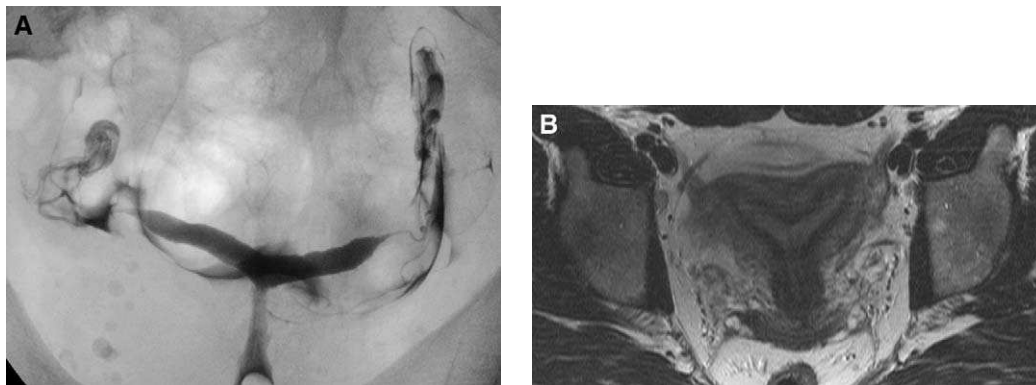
Bicornuate-septate uterus by hysterosalpingography (A) and MR imaging (B). The indentation of the serosal contour of the uterine fundus though small makes this technically bicornuate uterus, and likely not clinically significant. Correct categorization and determination of significance of uterine anomalies is debated by fertility specialists.
